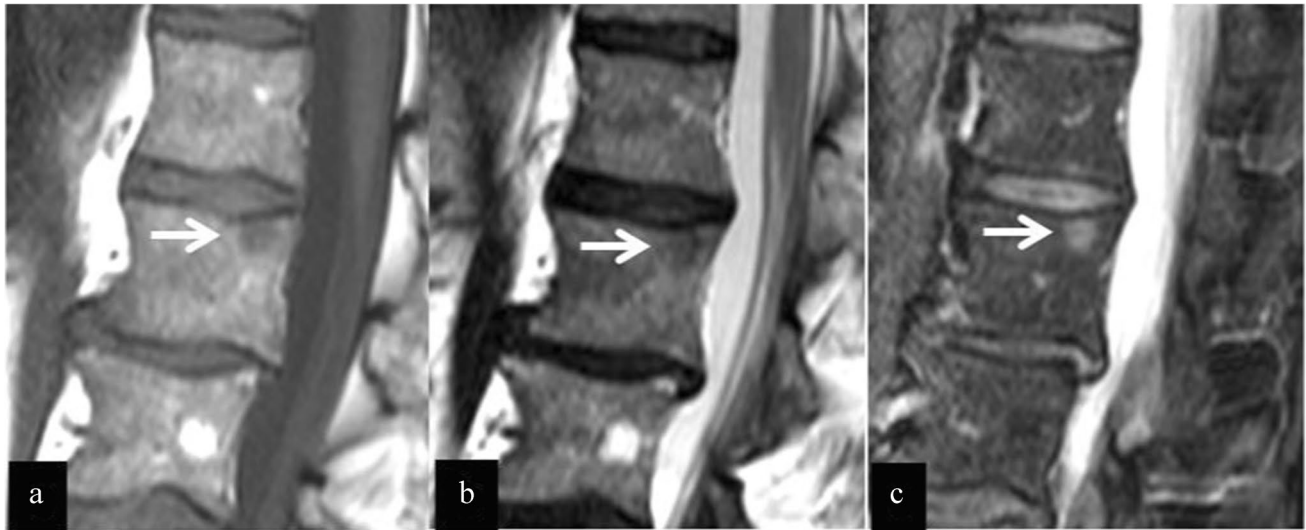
Sagittal MRI of the lumbar spine of a 65-year-old man with SD IIIA (ISS1) MM. An area with intermediate signal intensity on a T1 SE and b in-phase Dixon T2 images could be compatible with red marrow. However, its signal intensity on c the water-only Dixon T2
